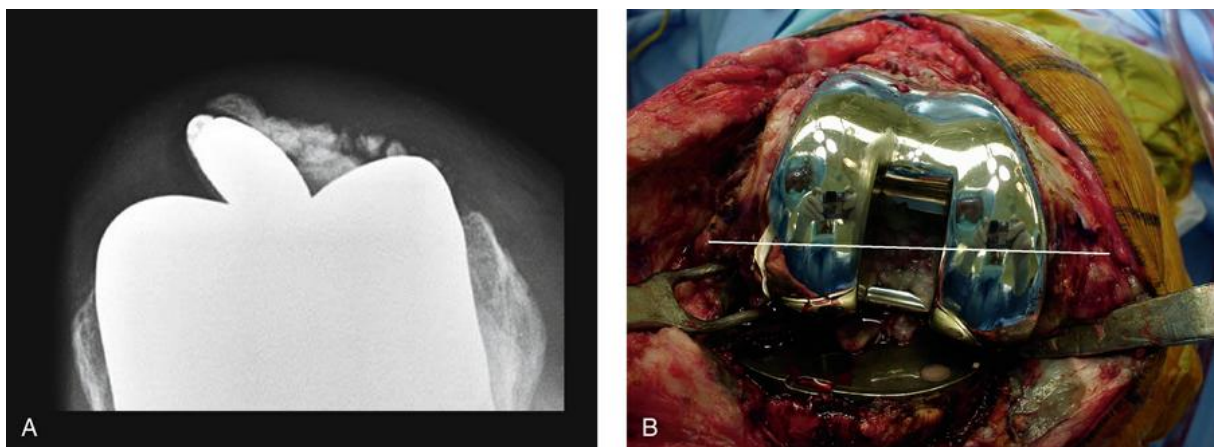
Images depict internal rotation of the femoral implant. A, Radiograph demonstrates considerable patellar tilt associated with an internally rotated femoral implant. B, Intraoperative view of the same knee demonstrates that the femoral implant is internally rotated relative to the epicondylar axis (white line).
